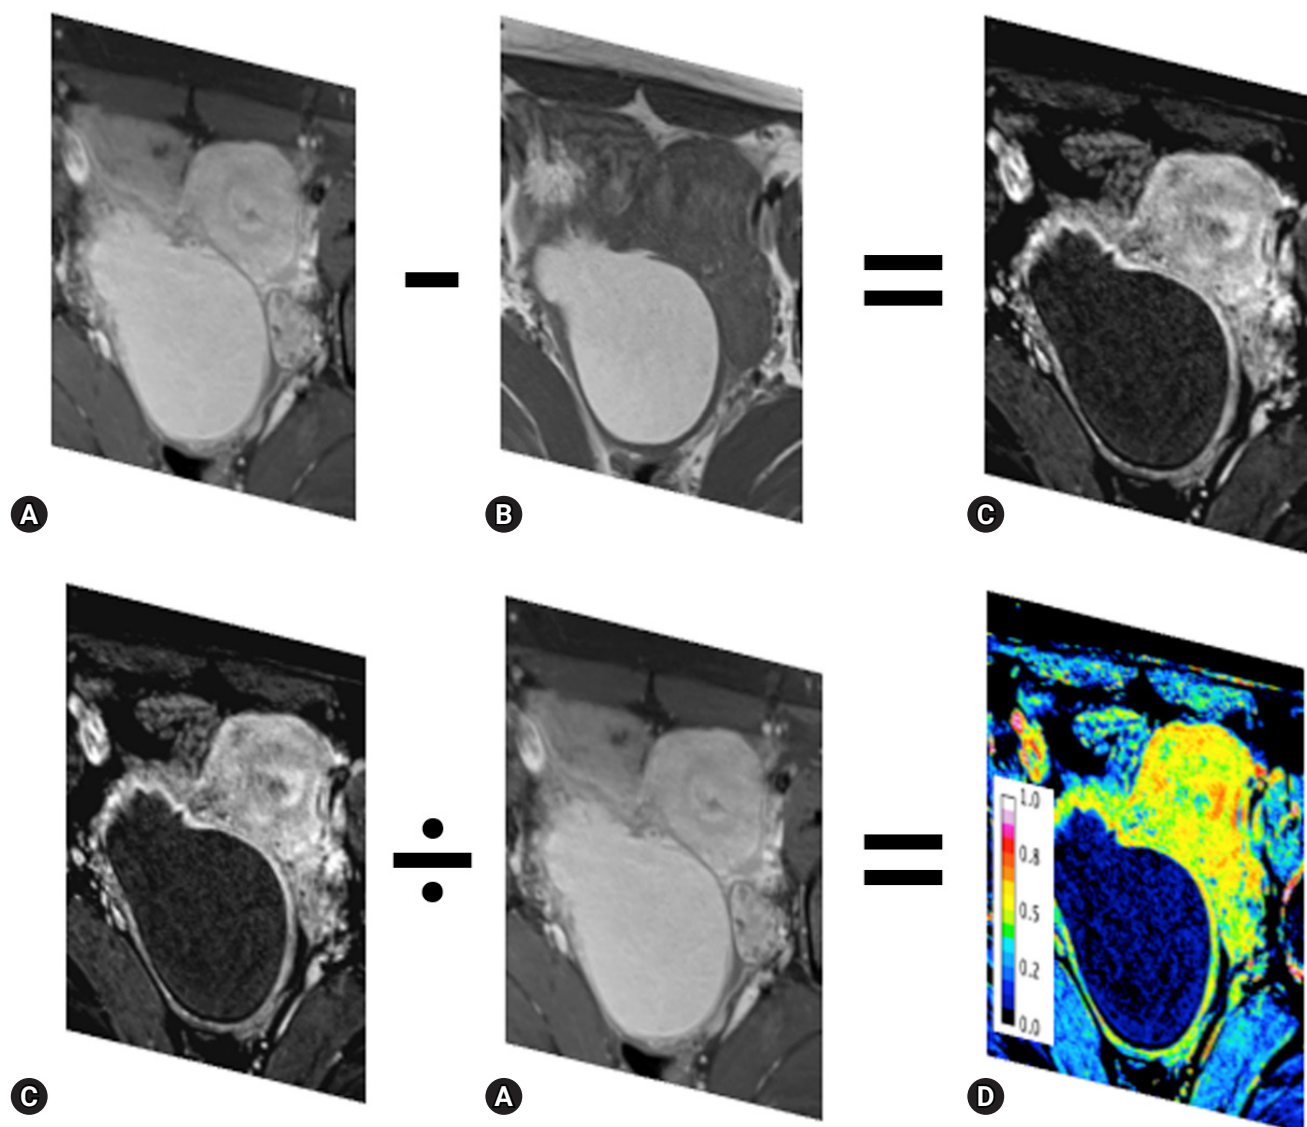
Subtraction imaging and normalization of the contrast-enhanced effect. The $^{ce}T1WI$ (A) is subtracted by the unenhanced T1WI (B) to yield the $^{sub}T1WI$ (C). To normalize the effect of contrast enhancement, the $^{sub}T1WI$ (C) is divided by the $^{ce}T1WI$ (A) using ImageJ. The normalized perfusion map (D) is scored 0–1. $^{ce}T1WI$, contrast-enhanced T1-weighted image; $^{sub}T1WI$, subtracted T1-weighted image.
